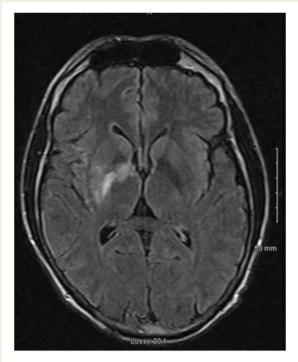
Magnetic resonance imaging brain depicting increased signal on FLAIR in the right basal ganglia involving the lentiform nucleus as well as the genu and anterior limb of the internal capsule.
